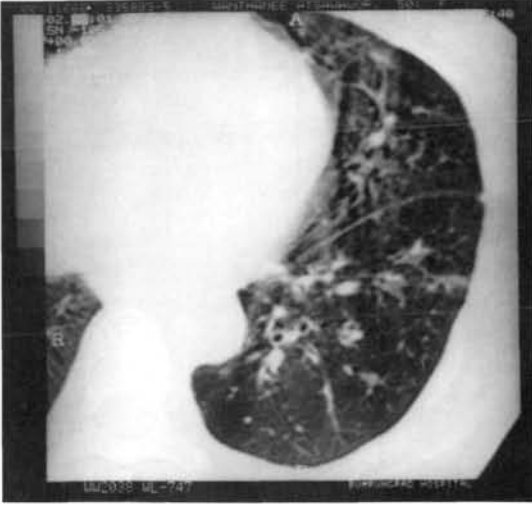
High resolution CT scan of the chest showing peribronchial thickening in bronchiolitis obliterans
